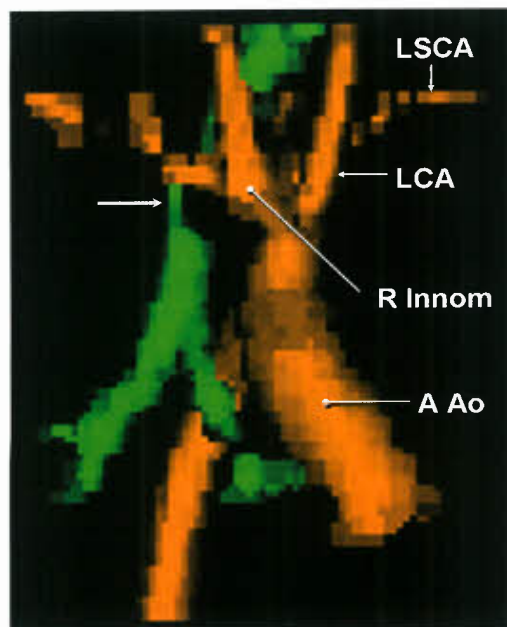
Innominate artery compression of the trachea. Right anterior oblique view of 3-D shaded surface display from MRI showing severely compressed midtrachea (arrow) adjacent to right innominate artery (R Innom).
